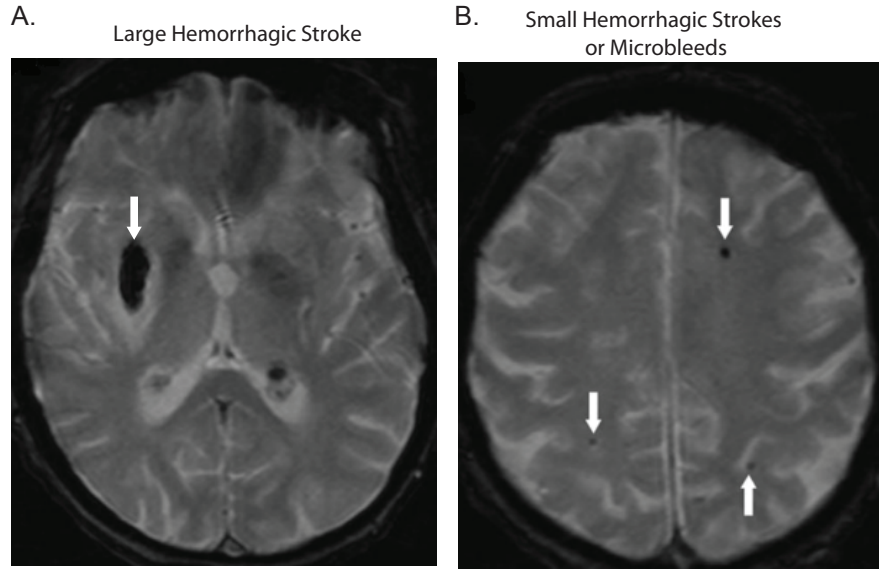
MRI of large and small hemorrhages in a 77 year old woman. A. Right putaminal intracerebral hemorrhage. B. Multiple microbleeds in the cortex and subcortex. Figure adapted from [80].
